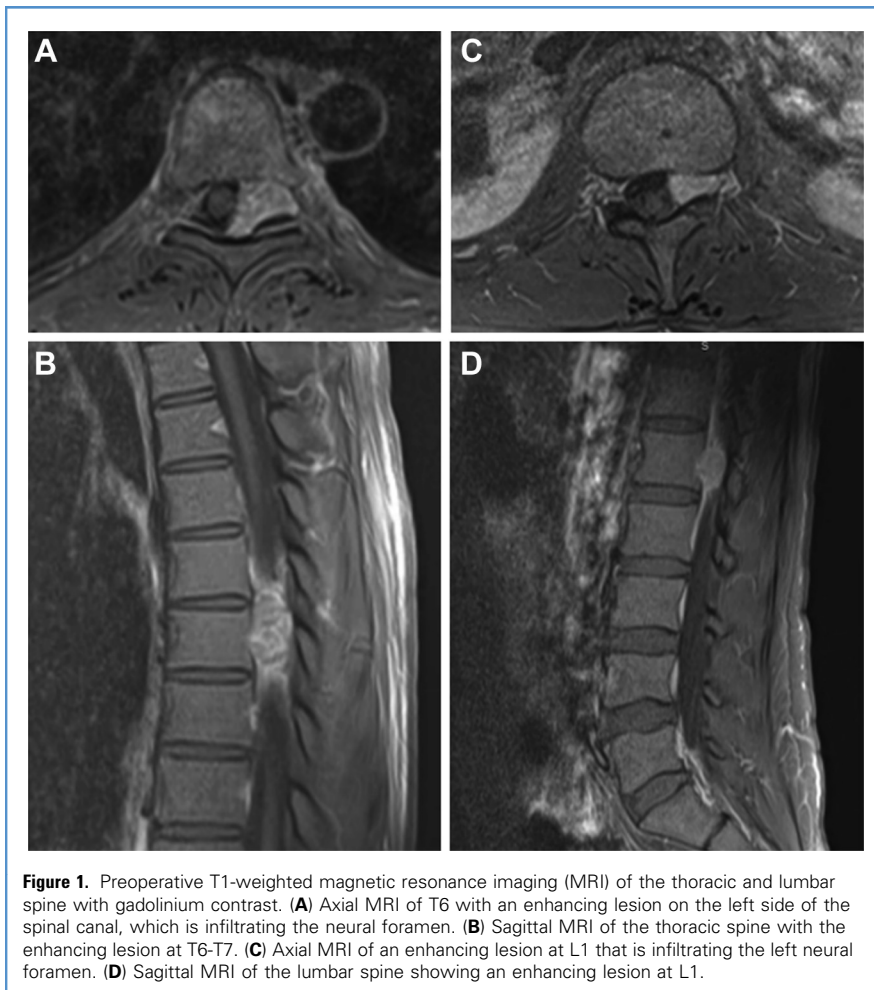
Preoperative T1-weighted magnetic resonance imaging (MRI) of the thoracic and lumbar spine with gadolinium contrast. (A) Axial MRI of T6 with an enhancing lesion on the left side of the spinal canal, which is infiltrating the neural foramen. (B) Sagittal MRI of the thoracic spine with the enhancing lesion at T6-T7. (C) Axial MRI of an enhancing lesion at L1 that is infiltrating the left neural foramen. (D) Sagittal MRI of the lumbar spine showing an enhancing lesion at L1.
